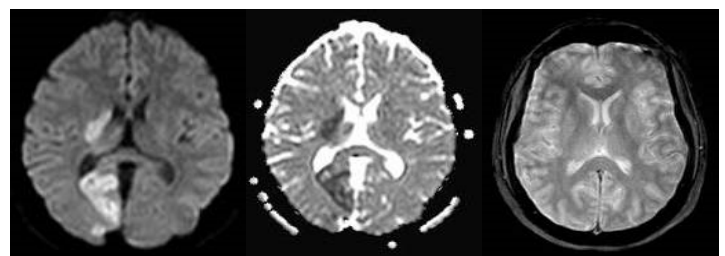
MRI DWI MRI ADC MRI Flair
